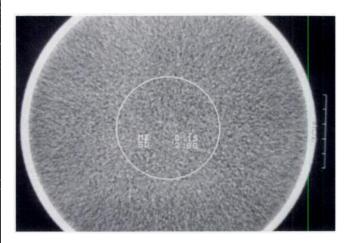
CT scan of a container of water in which a circular area of interest is indicated. Values for the mean (ME) and standard deviation (SD) of the CT numbers are shown.
